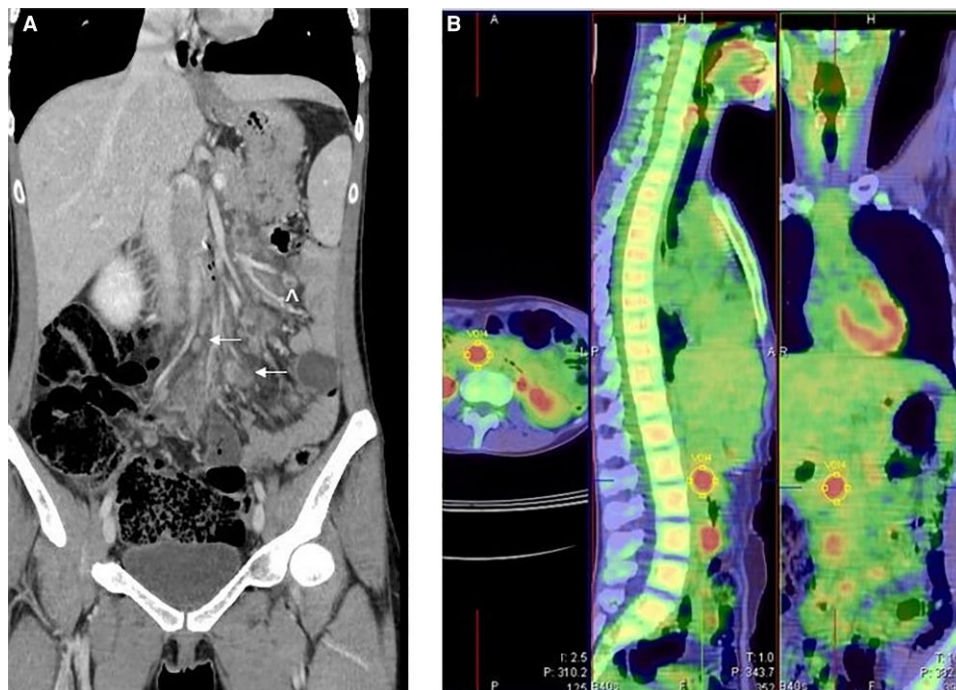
A, Coronal computed tomographic (CT) scan showing mesenteric panniculitis with enlarged lymph nodes (arrow) and necrotic lymphadenitis (arrowhead). B, CT-positron emission tomographic scan showing nodularity in the abdominal-pelvic area.
